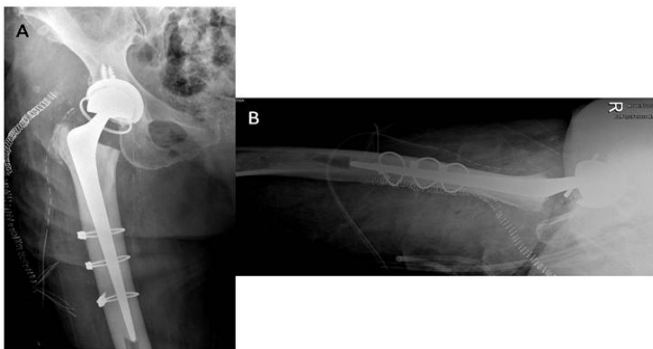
Postoperative x-ray (A: AP view; B: cross-table view).
